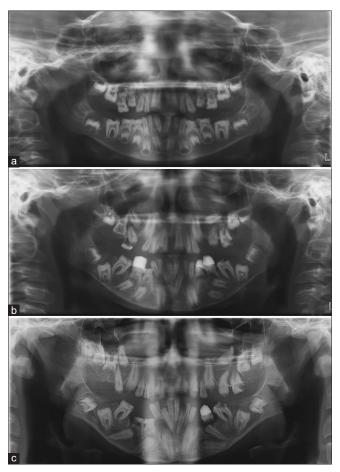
Sequence of panoramic radiographs showing the evolution of impaction of the teeth over 11 years. (a) 5 years. (b) 12 years. (c) 16 years
